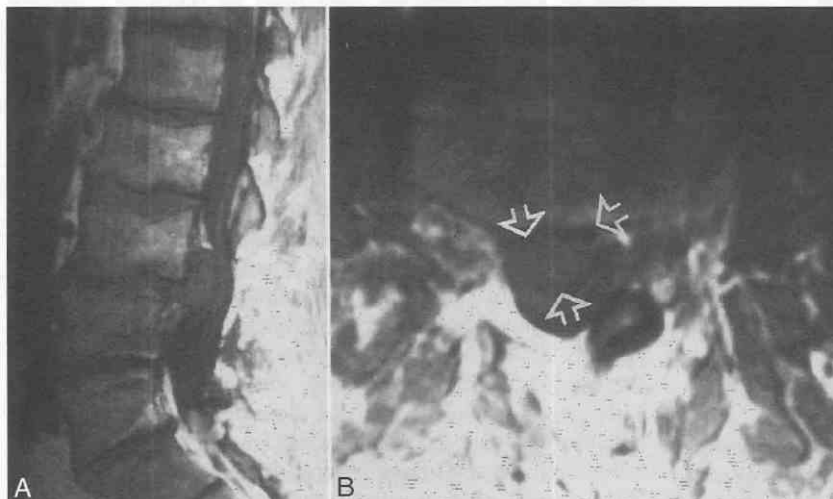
Postoperative disk herniation. *A*, Sagittal unenhanced MR image shows major disk herniation. *B*, Axial MR image after gadolinium administration shows no disk enhancement (arrows).
